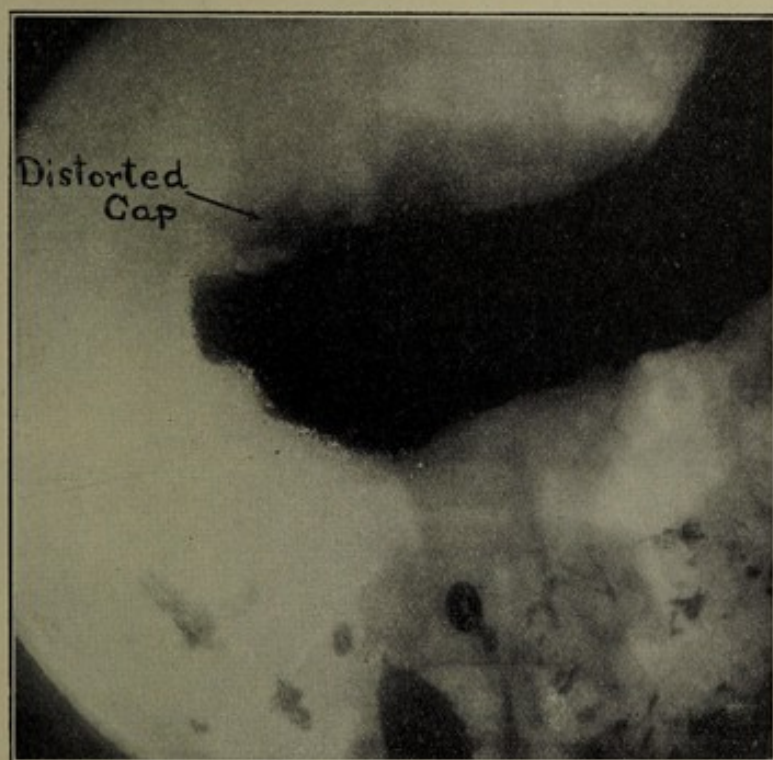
Permanent changes in cap, resulting from long-continued spasm, a reflex from chronic appendicitis. Resembles the roentgenographical appearance of cicatricial contraction from postpyloric ulcer.
